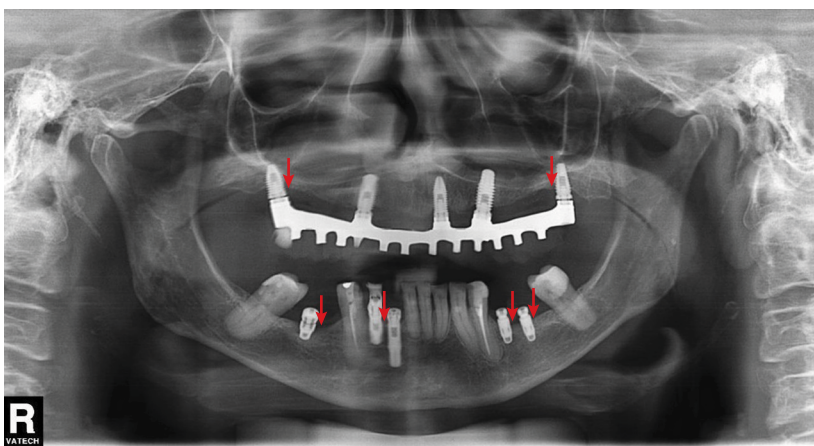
Panoramic radiograph showing five maxillary implants total denture over maxilla implant and five mandibular implants. Bone loss greater than 1.5 mm is observed (red arrows).
